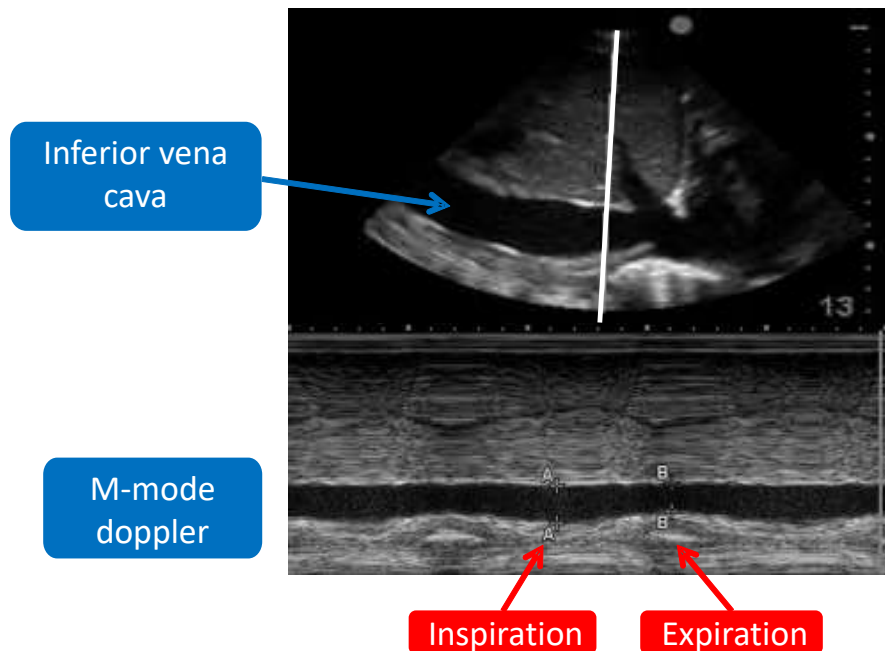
Subcostal echocardiography, in M mode, centered on the inferior vena cava, allowing measurement of variations in diameter in inspiration (A) and expiration (B).
